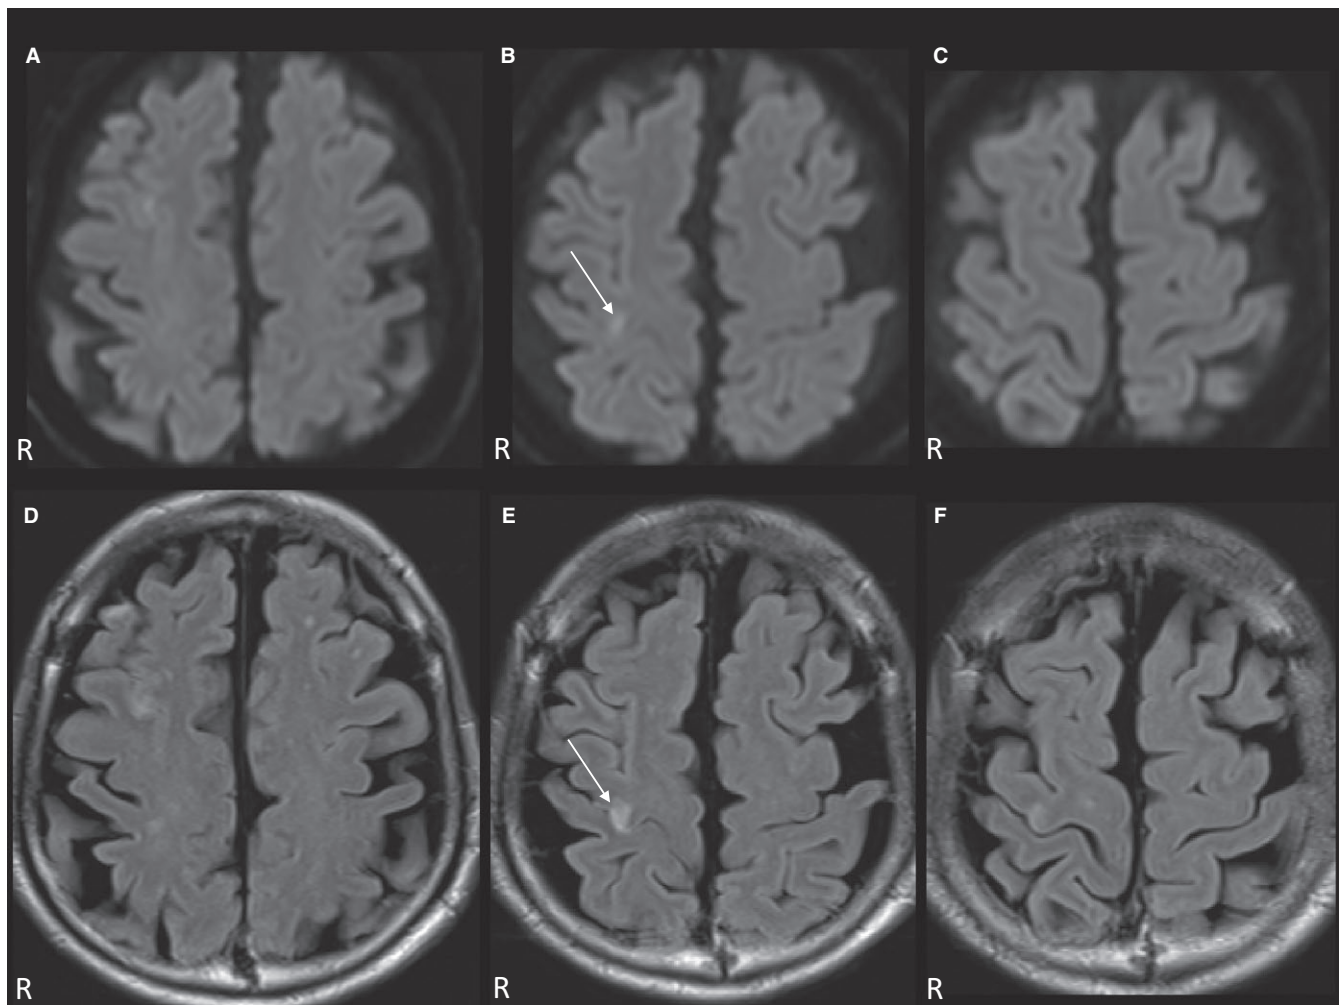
Brain magnetic resonance imaging demonstrated a localized infarction in the precentral and postcentral gyrus on the right side (A-C: diffusion-weighted, and D-F: fluid-attenuation inversion recovery, arrows)
